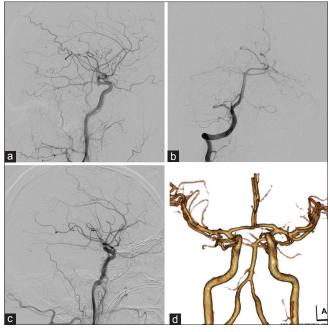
Lateral view on a right common carotid angiogram (a), anteroposterior view on a right vertebral angiogram (b), and lateral view on a left common carotid angiogram (c) showing no vascular abnormalities. (d) Postoperative 3D-CTA was also showing no vascular abnormalities
